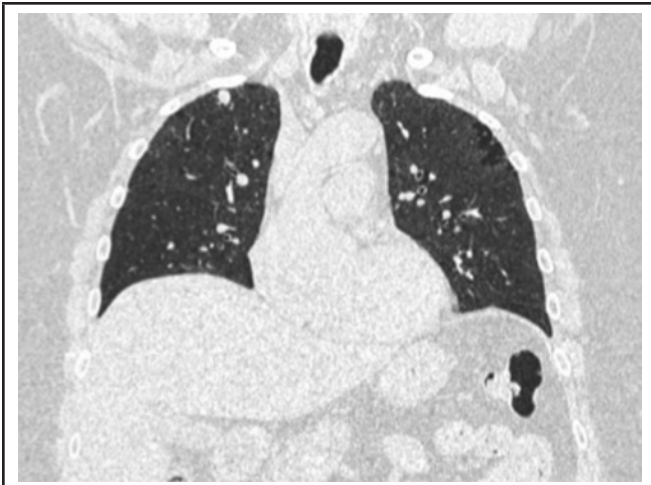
CT coronal cut, lung window, showing right upper lobe nodule
